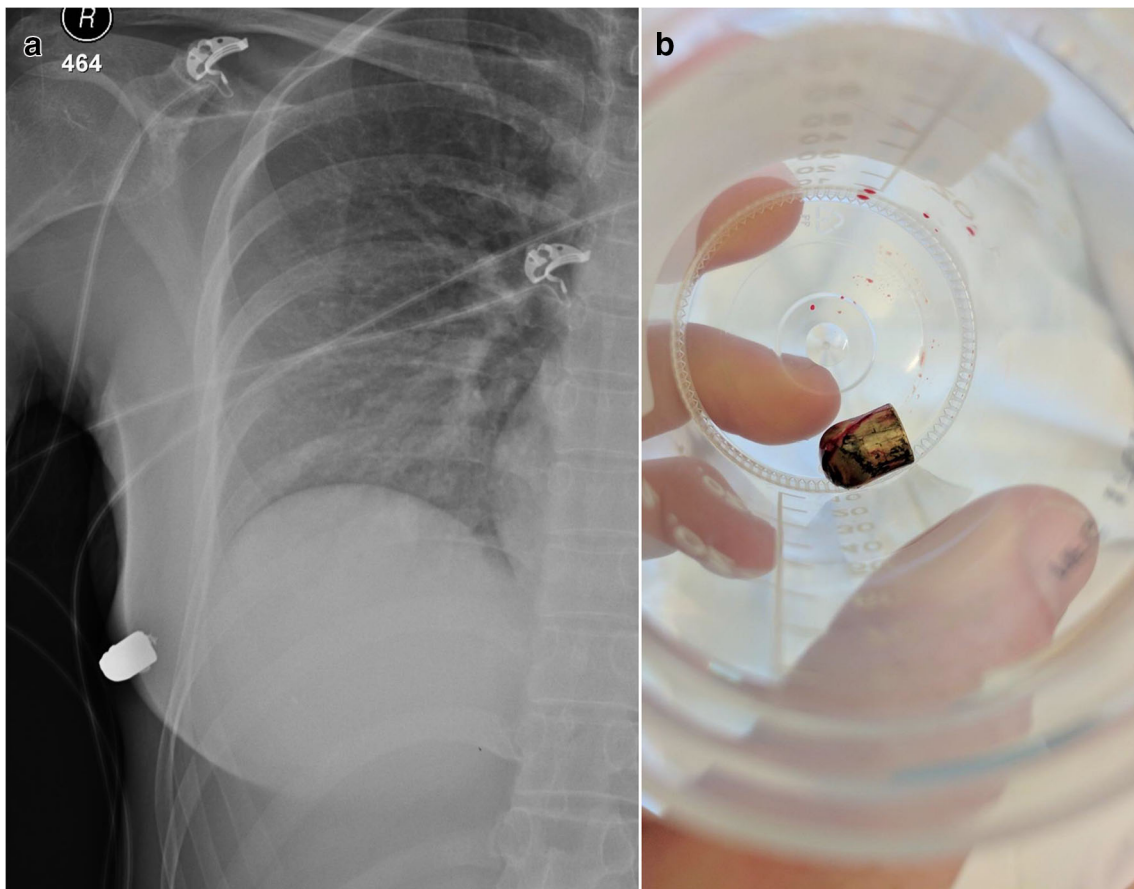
30-year-old female sustained a single bullet wound to the anterior thoracic wall, and a PA chest radiograph was acquired in the trauma bay. Lodged within the patient’s right breast is an intact bullet, an appearance
